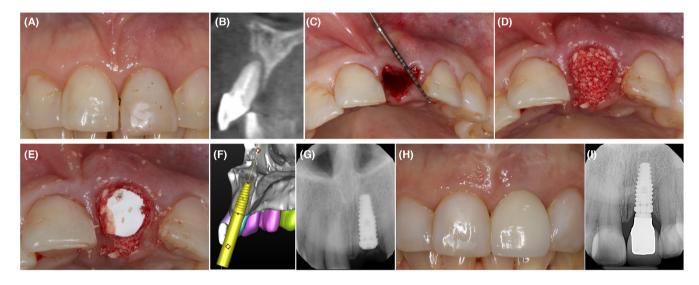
Flapless alveolar ridge preservation with freeze-dried bone allograft (FDBA) and rhPDGF-BB. (A) Baseline. (B) Cone beam computed tomography scan at baseline. (C) Clinical view after the extraction showing the lack of buccal bone of the extraction socket. (D) The socket was grafted with FDBA soaked with rhPDGF-BB. (E) A collagen membrane was applied on top of the bone allograft. (F) Digital planning of implant therapy after 4 months. (G) Implant placement 5 months after alveolar ridge preservation. (H, I) Clinical and radiographic outcomes at 5 years.
